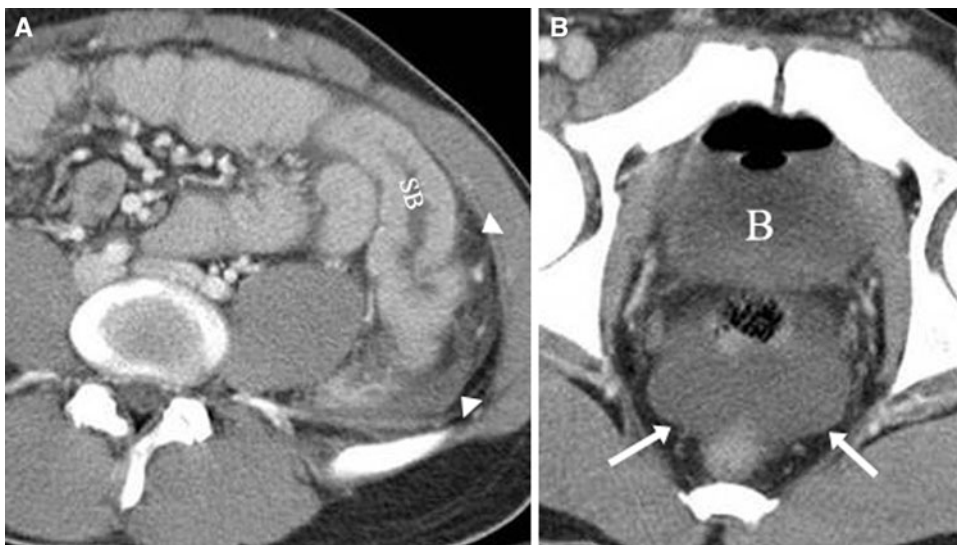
A 20-year-old male status post-blunt abdominal injury. A Axial contrast-enhanced CT of the abdomen demonstrated wall thickening of a small bowel loop (*SB*) in the left abdomen with adjacent fat stranding (*arrowheads*). B Axial contrast-enhanced CT of the pelvis demonstrated a moderate amount of free fluid (*arrows*) with attenuation 26 HU. Bladder (*B*) is noted. Jejunal perforation was identified at surgery.
